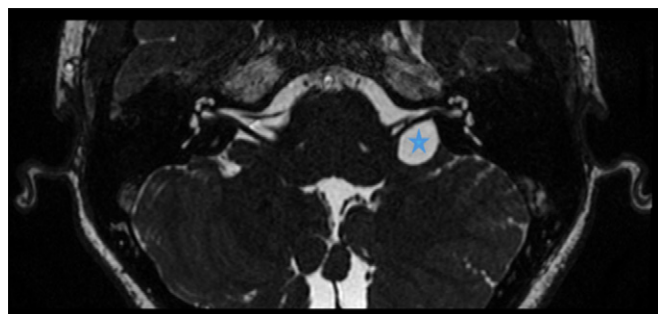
Axial T2-weighted driven equilibrium radio frequency reset pulse images of the ears reveal an arachnoid cyst on the left cerebellopontine angle (star), deviating the vestibulocochlear nerve complex anterior and inferiorly, resulting in asymmetry of the internal auditory canals, both of which are permeable. Evaluation of the brainstem and cranial nerves VII and VIII was unremarkable.
